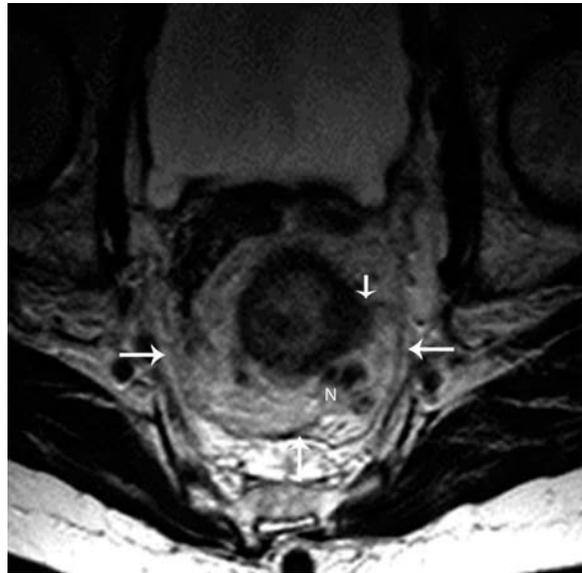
Stage T3 N1 rectal carcinoma in a 72-year-old male. Axial T2-weighted image demonstrates extension of the intermediate T2 signal intensity rectal carcinoma into the left perirectal fat (short arrow). Tumor does not breach the mesorectal fascia/circumferential resection margin (long arrows). Also note prominent regional perirectal lymph nodes (N).
